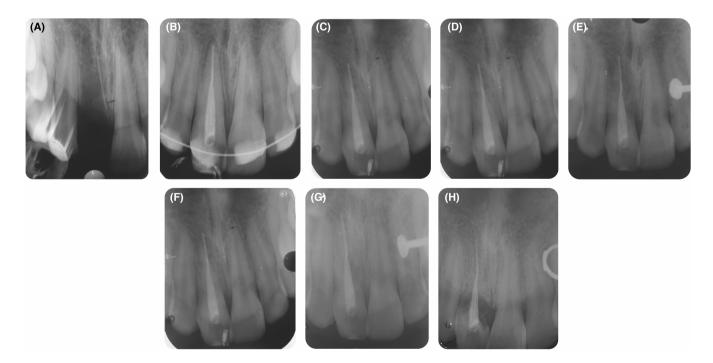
Intraoral periapical radiographs before replantation and post-replantation follow-up visits. (A) Preoperative. (B) After replantation of avulsed tooth and splinting. (C) Four-week follow-up. (D) Six-month follow-up. (E) Twelve-month follow-up. (F) Nineteenmonth follow-up. (G) Five-year follow-up. (H) Six-year follow-up.
